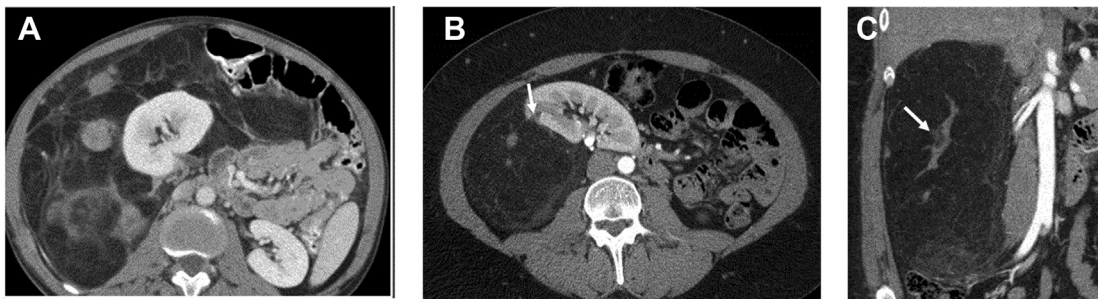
Liposarcoma versus large AML. (A) CT image of dedifferentiated retroperitoneal liposarcoma with abundant fat and soft tissue nodules. (B) Large AML also appears as predominantly fat attenuation but also demonstrates a tiny renal parenchymal notch (*arrow*) and (C) has large central vessels (*arrow*).
